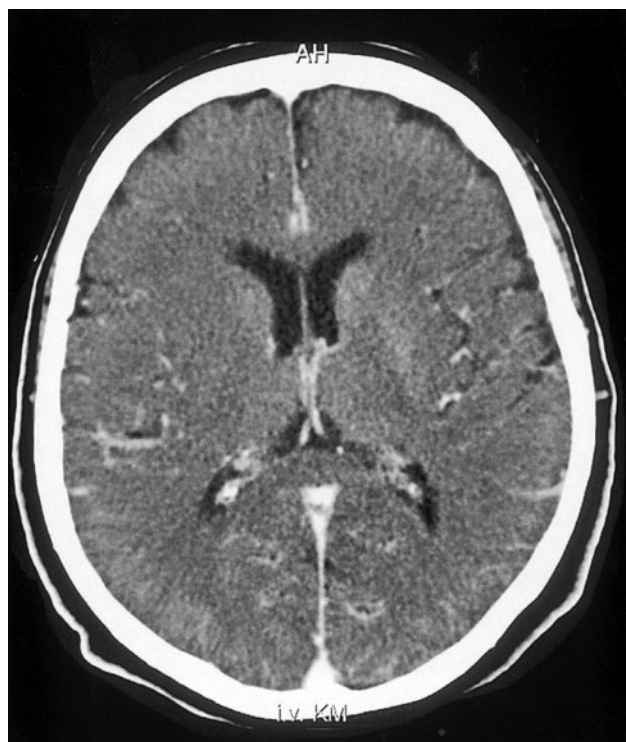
Computed tomography with contrast enhancement showing signs of diffuse anoxic lesions of the brain. Of note is the blurred delineation of the cerebral cortex and basal ganglia on the right side.
